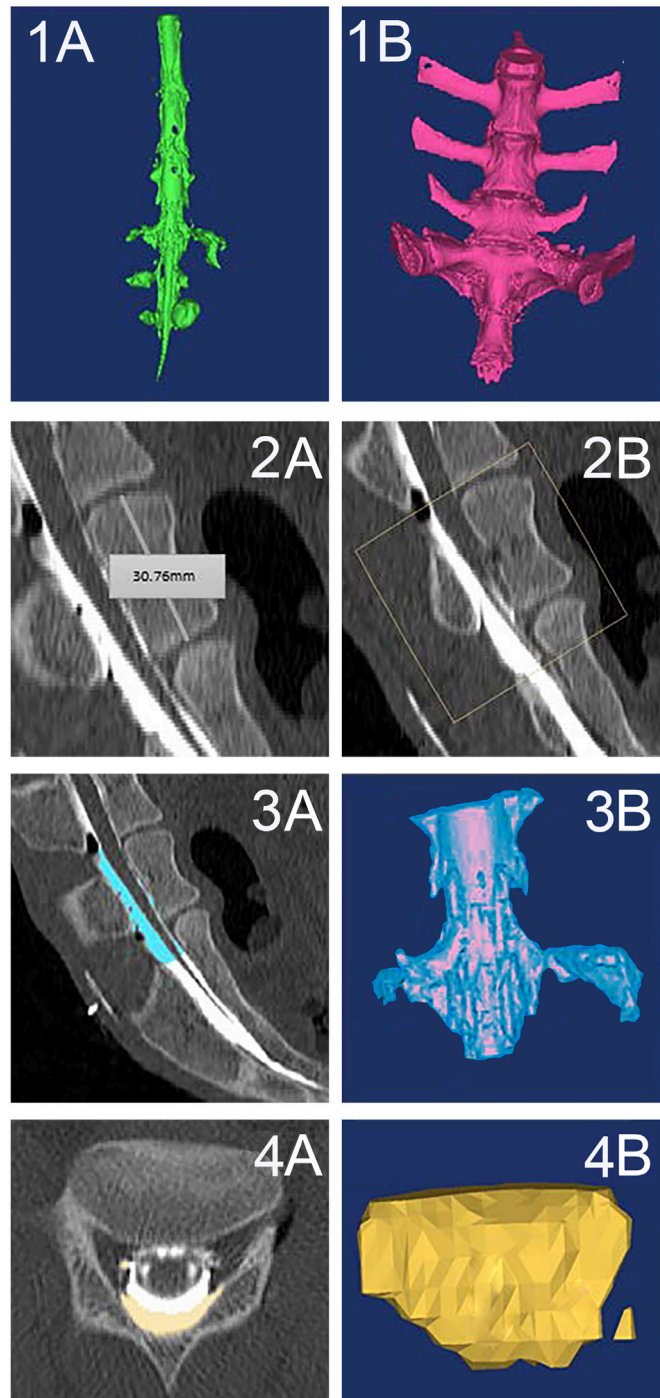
Analysis of the procedure used. (1A) is a 3D reconstruction (anteroposterior view) of all contrast liquid seen in the CT study. (1B)–(3D) reconstruction of bony elements in lumbosacral region (anteroposterior view). (2A) and (2B) Delimitation of the region of interest (ROI), sagittal view. (3A) and (3B) Contrast liquid identification in the ROI in light blue (3A and 3B) showing the sagittal view and 3D reconstruction in the anteroposterior view, respectively. (4A) and (4B) Inside the ROI, and selection and quantification of contrast in the epidural area in yellow. (4A) shows a cross-section of CT and the epidural contrast is marked in yellow. Online supplemental material and (4B) show an axial cross-section and an anteroposterior view of 3D-reconstructed epidural contrast in the ROI, also marked in yellow, respectively. The color on the surface of the images was modified using Adobe Photoshop (Adobe, San Jose, California, USA). The texture was kept and the color was added to make the images easier to understand.
